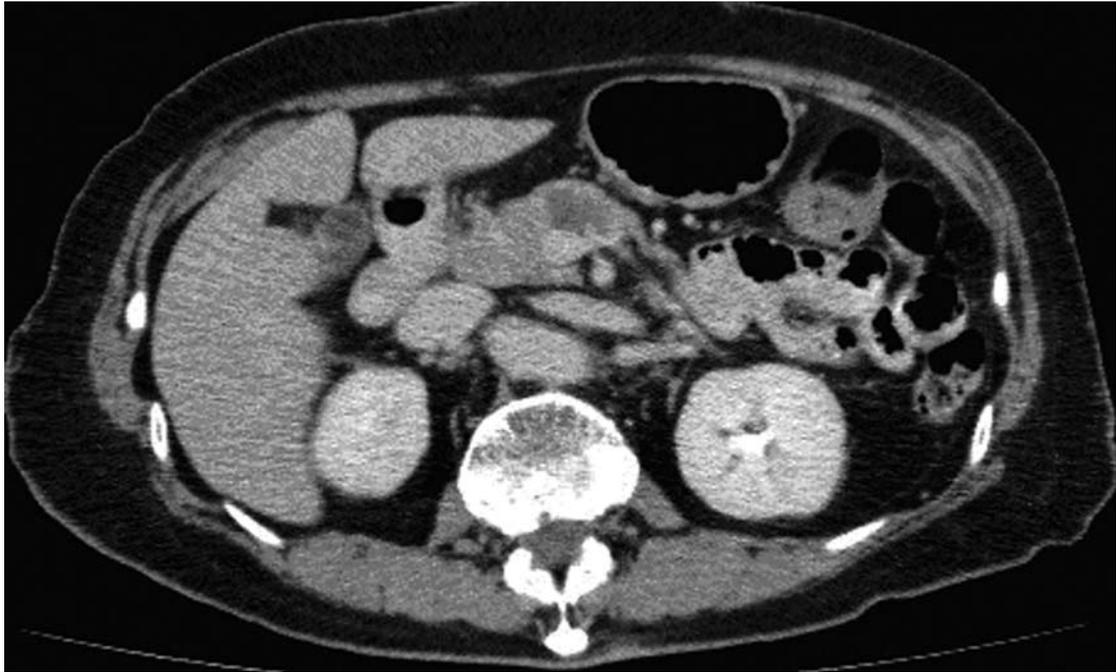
A serous cystadenoma appeared as a non-descript cystic lesion on CT.
